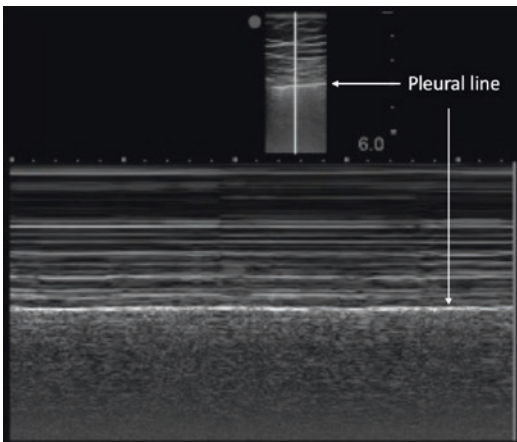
Linear probe M-mode ultrasound image demonstrating the “Seashore sign” (lower image). The upper image is the corresponding 2D ultrasound view
